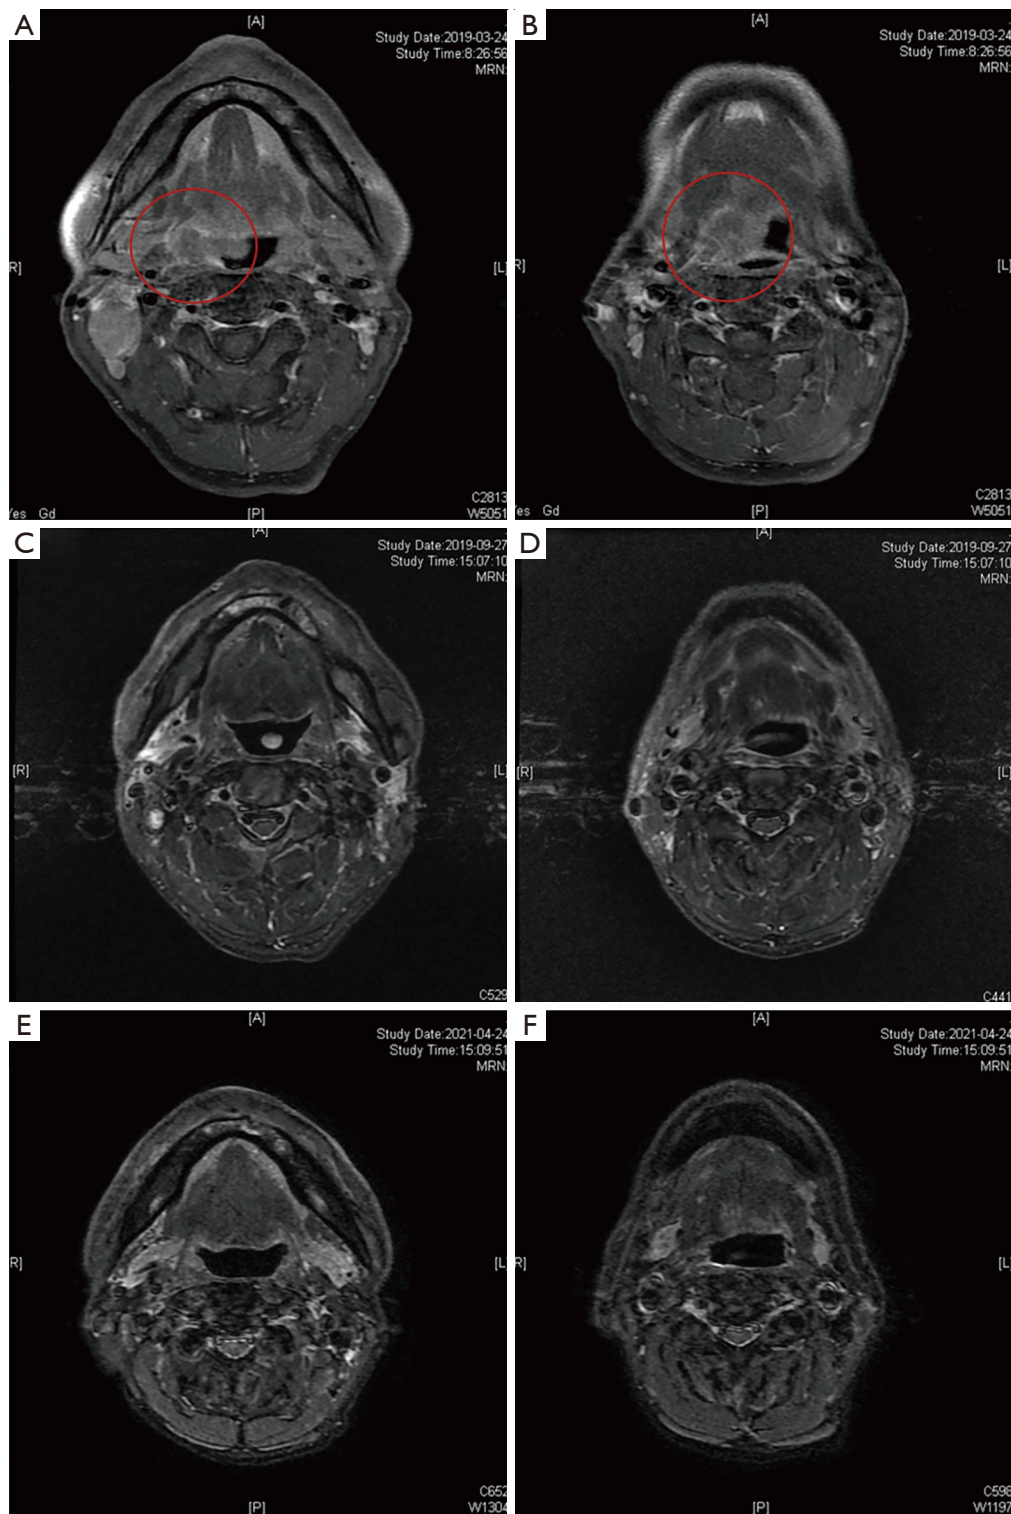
MRI of the head and neck. (A,B) Tumor masses in the right tongue base and right oropharynx on March 24, 2019. (C,D) The mass disappeared after radiotherapy in the head and neck on September 27, 2019. (E,F) Good disease control was observed in the latest examination of the patient on April 24, 2021. The red circle indicates the location of the tumor. MRI, magnetic resonance imaging.
